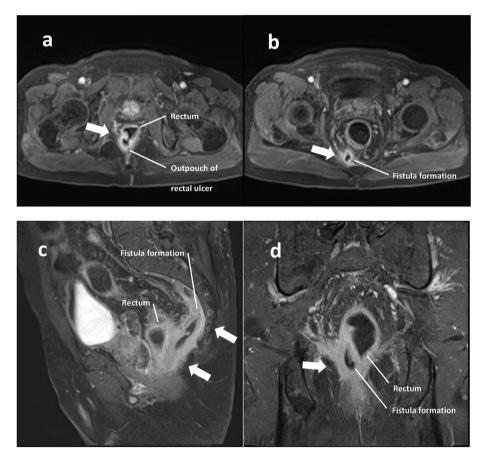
Pelvic MRI with contrast enhancement (T1-weighted fast spin echo [FSE] images). a b, Transverse view: a deep ulcer with fistula formation at right posterior rectal wall. c, Sagittal view: the estimated depth of the ulcer was about 6 cm with fat stranding of the perirectal fascia. d, Coronal view: an outpouching ulcer with fistula formation (arrows).
